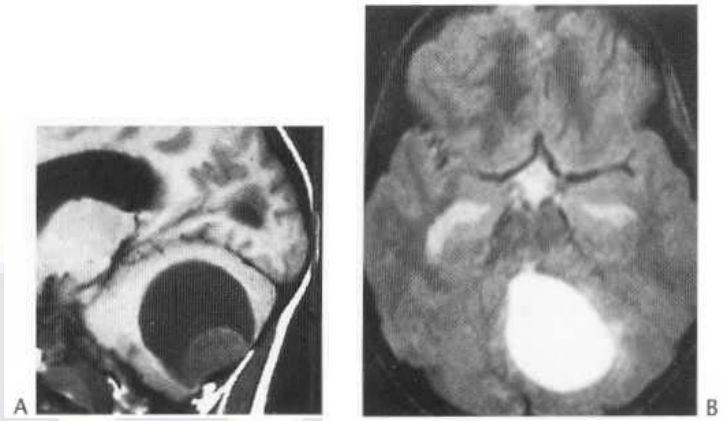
MRI studies of cystic juvenile astrocytoma. (A) T₁-weighted: tumour and cyst are of different low signals. (B) T₂-weighted: tumour and cyst given uniform high signal.
